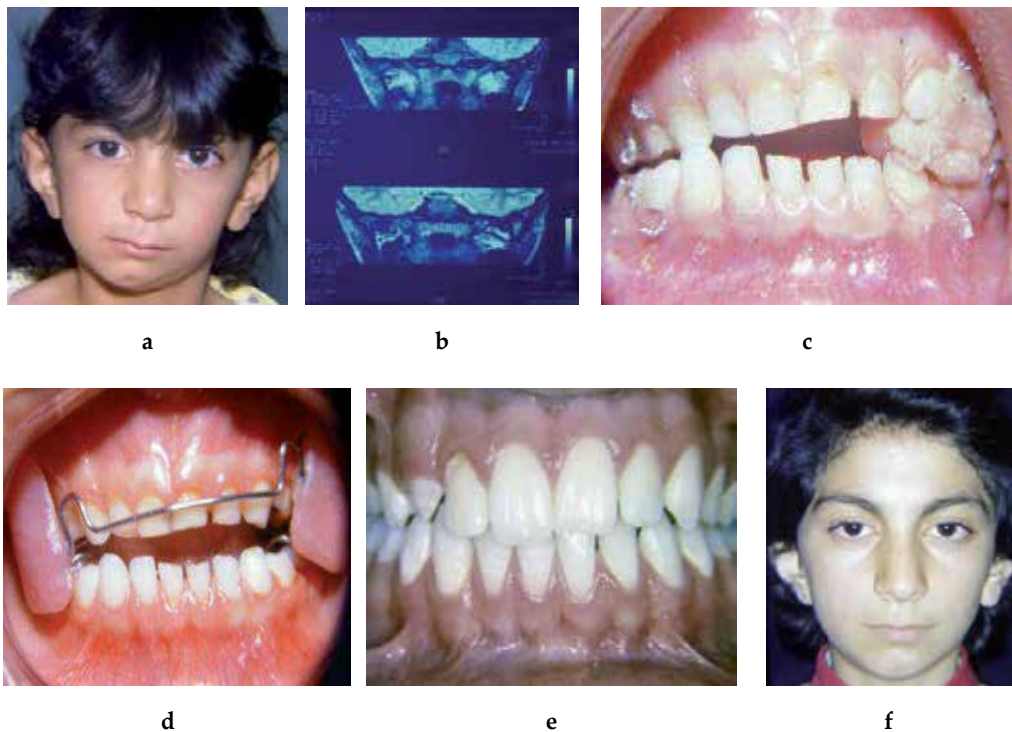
a) Facial view of a 5 year-old boy, b) MRI before any orthodontic intervention, c) postoperative openbite immediately after surgery to free the ankylosed condyle, d) Insertion of a hybrid functional appliance for differential dental eruption, e) occlusion of the patient. The remarkable improvement from unilateral condylar ankylosis and subsequent normal symmetric growth of facial structure was achieved. The functional appliance was also worn at night during the growth period. f) Final facial view
